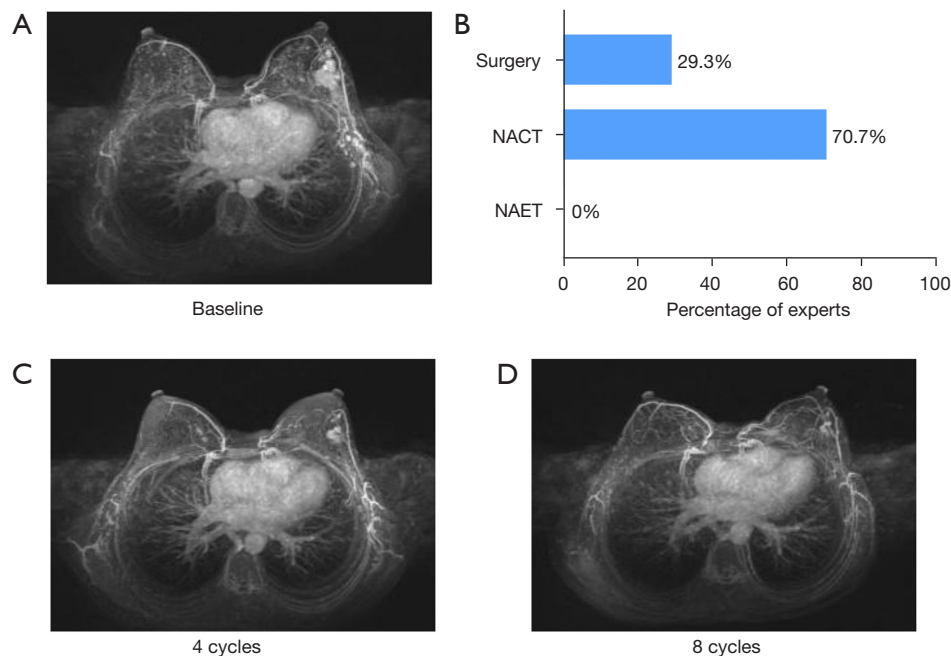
MRI scan during neoadjuvant treatment and expert opinions for therapy recommendation. (A) MRI scan of breast cancer and axillary lymph nodes in baseline detection. (B) Expert opinions for therapy selection. (C,D) MRI scan of breast cancer and axillary lymph nodes responses after 4 cycles (C) and 8 cycles (D) of neoadjuvant treatment. NACT, neoadjuvant chemotherapy; NAET, neoadjuvant endocrine therapy; MRI, magnetic resonance imaging.
